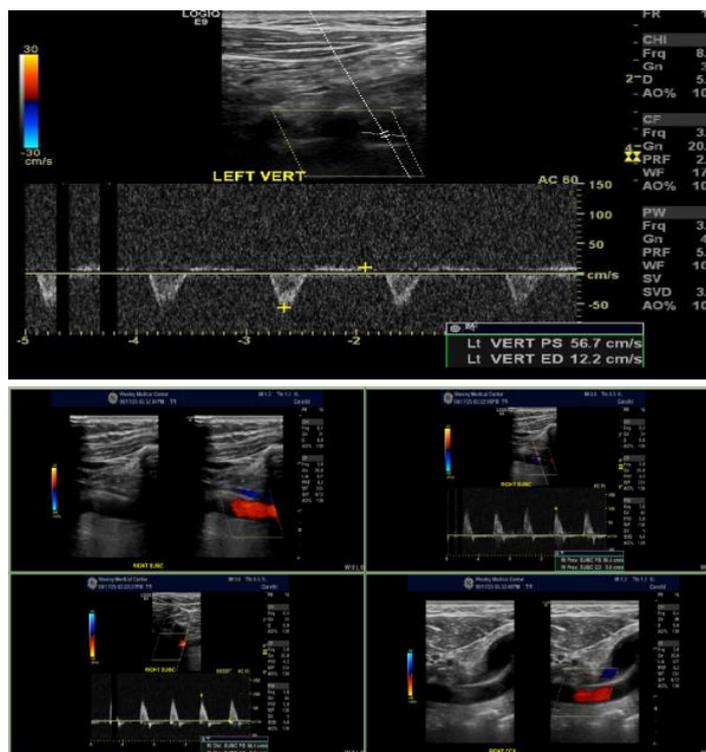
USG color Doppler - Since left subclavian stenosis is present, blood flow is coming from the right side and going to the left vertebral artery. The downward deflection in vertebral artery indicates the backward rerouting of blood into the arm vessels instead of supplying the brain. As this stealing of blood occurs in the context of less than adequate collateral circulation in the posterior brain, cerebral ischemia can be the ultimate result. This anomalous circumventing of blood can be instigating the transient ischemic attack and stroke in this patient
